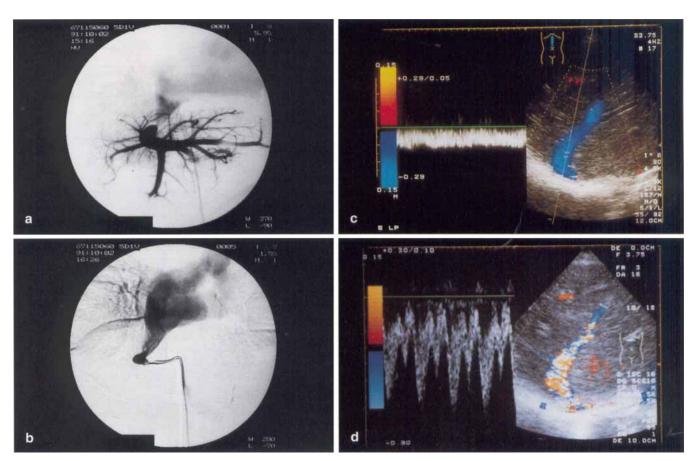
Radiographs of angioplasty for hepatic vein stenosis and Doppler US findings of the hepatic vein in case 1: a Hepatic venography shows severe stenosis of the hepatic vein anastomosis before angioplasty. The flow of contrast medium toward the right atrium is delayed and peripheral branches of the hepatic vein are enhanced; b PTA relieves the anastomotic stenosis and flow of contrast medium toward the right atrium is clearly obtained; c Before PTA, the flow velocity in the hepatic vein is decreased with a loss of pulsatility in the Doppler waveform; d Doppler spectrum of the hepatic vein after PTA shows a biphasic waveform pattern with a remarkable increase in the flow velocity
